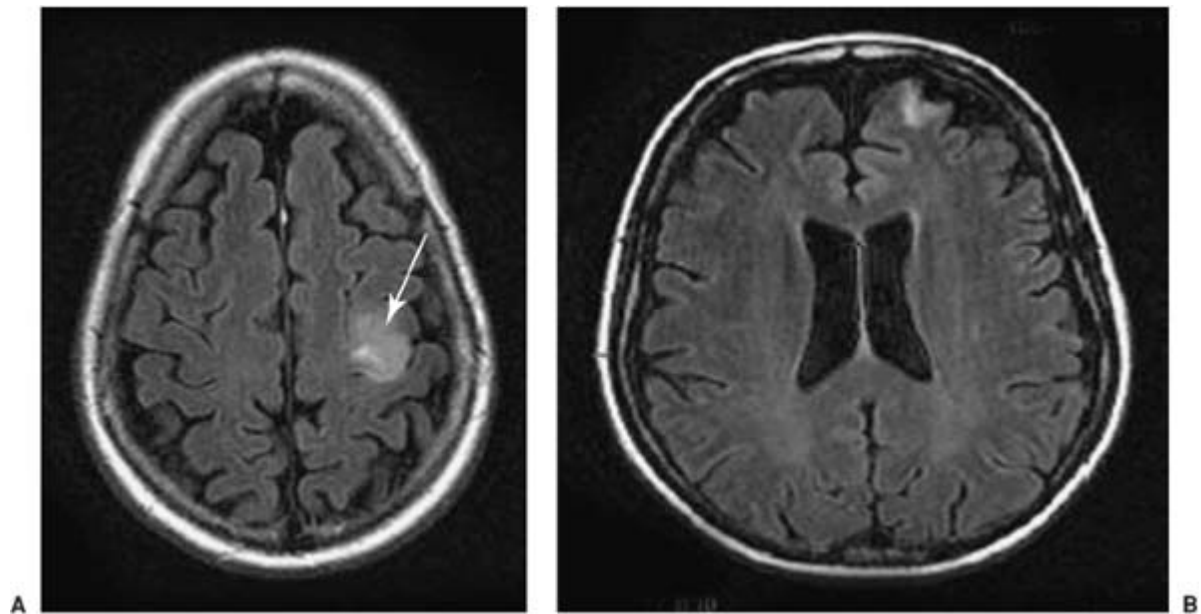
Fluid-attenuated inversion recovery (FLAIR) images can sometimes make lesions easier to see. This image shows a focal lesion in the middle frontal gyrus (*arrow*, panel A). This would be seen easily on a
